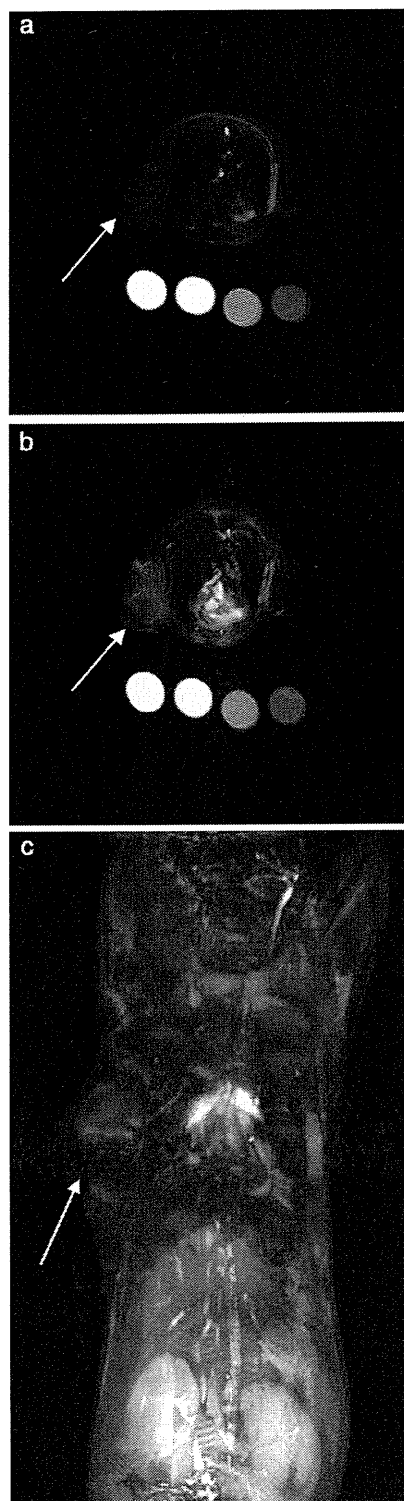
Axial slices of MR images (a) before and (b) 24 h after the injection at a dose of 0.05 mmol Gd/kg. Tumor areas are on the left side in the axial slices. The circles indicate the stock solutions of (left to right) 1.0 mM, 0.5 mM, 0.1 mM gadolinium ion in agarose gel and blank in agarose gel. T₁-weighted gradient echo protocol was used. Parameters of the T₁-weighted images were TR/TE=8.0/4.5, flip angle=30°, field of view of 45×45 mm, a matrix size of 192×192, and 2 mm of axial slice thickness. Arrows indicate tumor tissue. (c) MIP images of coronal slices 24 h after injection. Arrow indicates tumor. Parameters of the T₁-weighted images were TR/TE=8.0/4.2, flip angle=30°, field of view of 50×30 mm, a matrix size of 192×192. MIP images were obtained by 2 mm thickness×4 slices.
